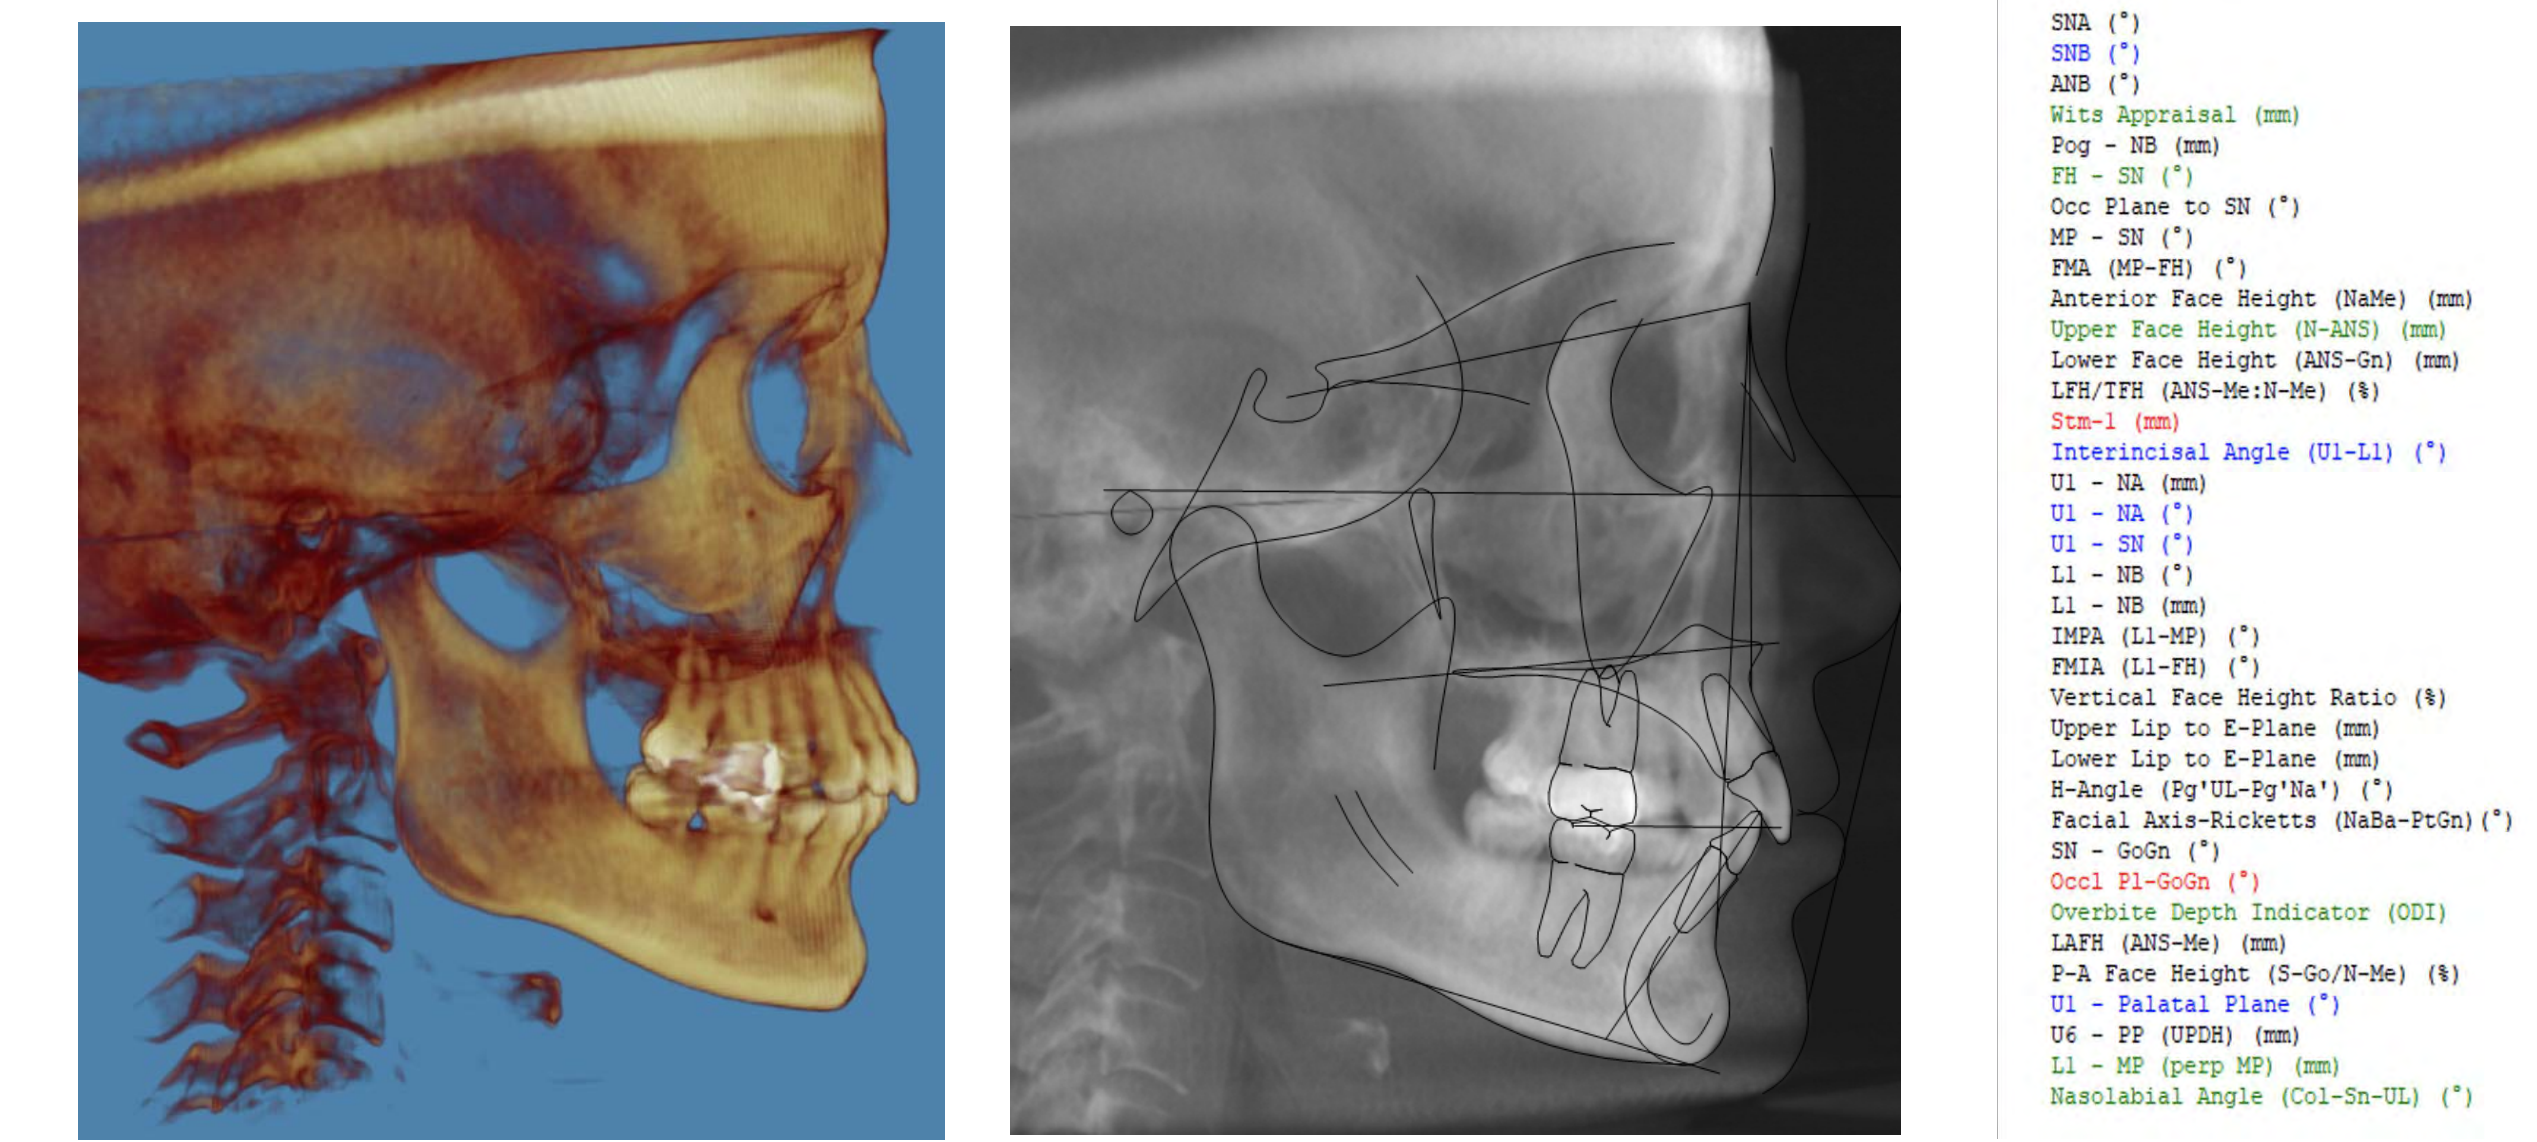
CBCT from the patient (left); Lateral x-rays were created from the CBCT (middle) and the cephalometric measurements were obtained (right).
